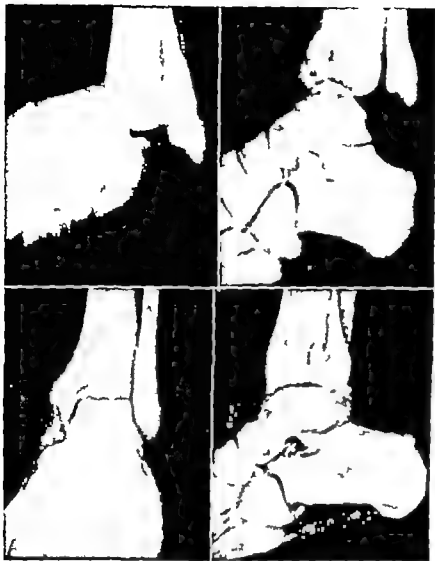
Dislocation of the talus away from the leg. (A, Top left) Anteroposterior view roentgenogram of the ankle of an obese woman who suffered a compound dislocation with the ankle joint gaping wide open laterally (B Top right) Lateral view (C Bottom left) Anteroposterior view — roentgenogram 18 months after open reduction and reconstruction of the deltoid ligament, using half of the tibialis posterior tendon for tenodesis. The patient recovered with no traumatic flatfoot. (D Bottom, right) Lateral view Talus shows no sign of avascular necrosis.
